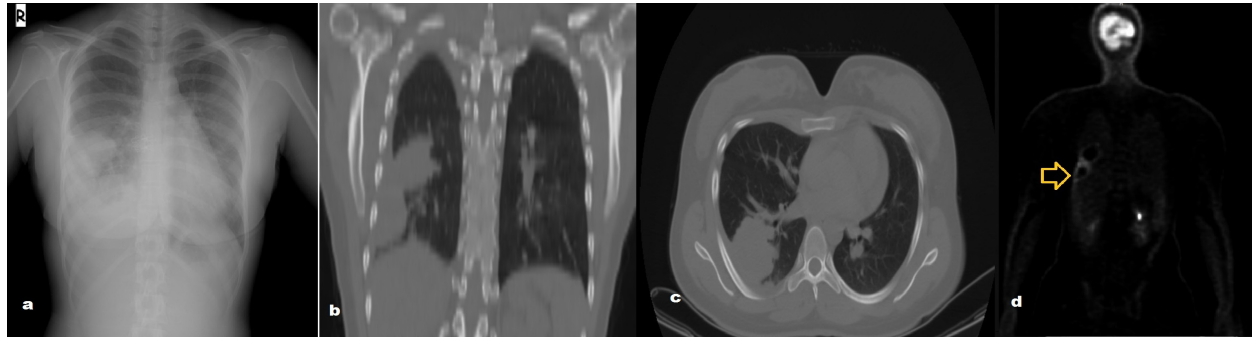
a) Chest xray shows density on right inferior lobe b)CT coronal plane c)CT axial plane d)PET-CT
